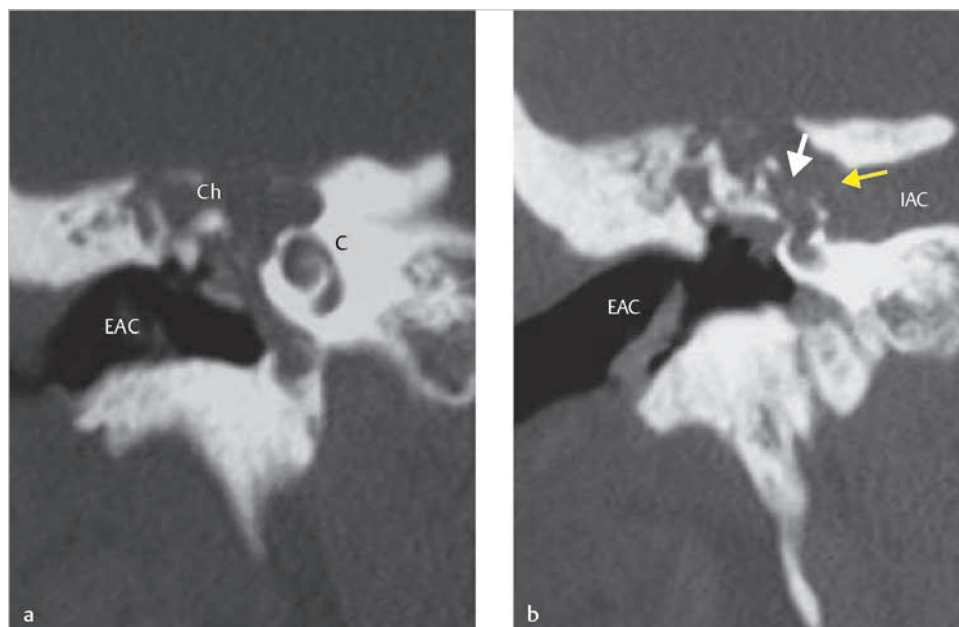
The coronal CT (a) shows presence of cholesteatoma superiorly to the cochlea, involving the area of the geniculate ganglion. More posterior section (b) shows extensive bone erosion at the fundus (yellow arrow) and the vestibule (white arrow). C, cochlea; Ch, cholesteatoma; EAC, external auditory canal; IAC, internal auditory canal.
